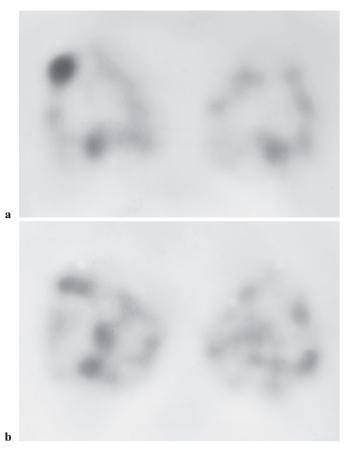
a ¹⁸F-fluoro-2-deoxy-D-glucose (FDG)-positron emission tomography (PET) shows an obvious accumulation in the right knee, corresponding to the cystic lesion of the patella, with a standardized uptake value (SUV) of 1.4. b In contrast, L-[3-¹⁸F]-alpha-methyl tyrosine (FMT)-PET analysis showed obscure accumulation of FMT. (SUV, 0.60)
